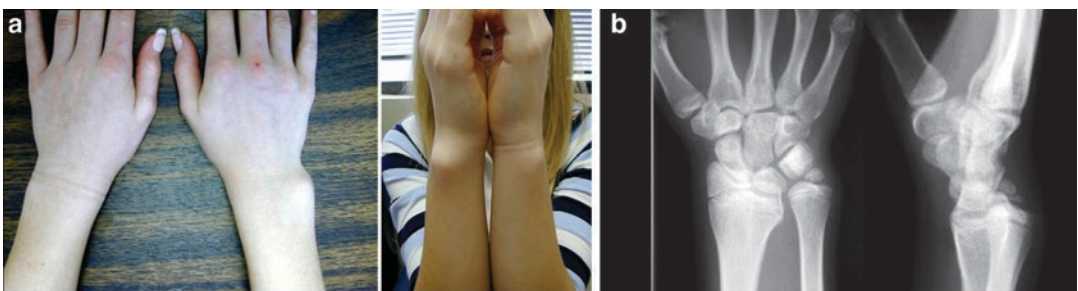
(a) Clinical photographs and (b) PA and lateral wrist radiographs of a patient with post-traumatic Madelung's deformity from a traumatic injury to the volar
